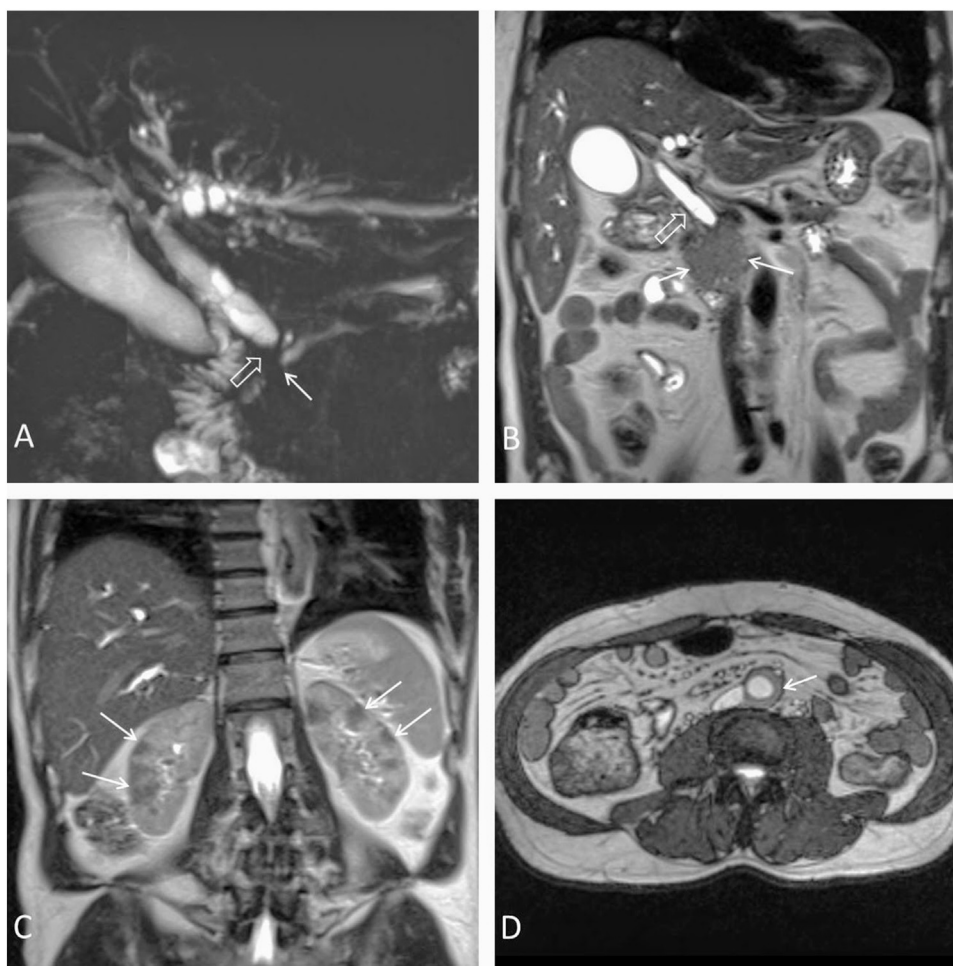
MR imaging of the abdomen in IgG4-related disease.
